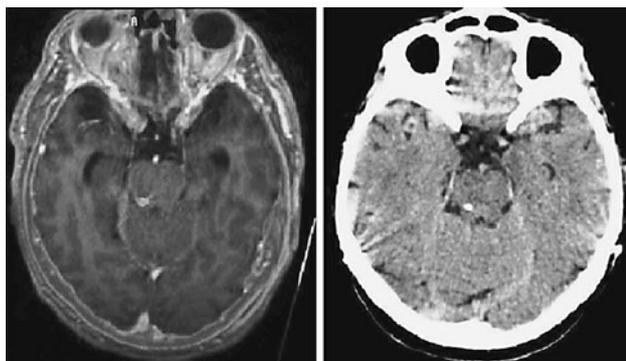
Postoperative MRI (*left panel*) and CT (*right panel*) axial section showing the tip of DBS leads within the right PPN nucleus in the two reported patients
